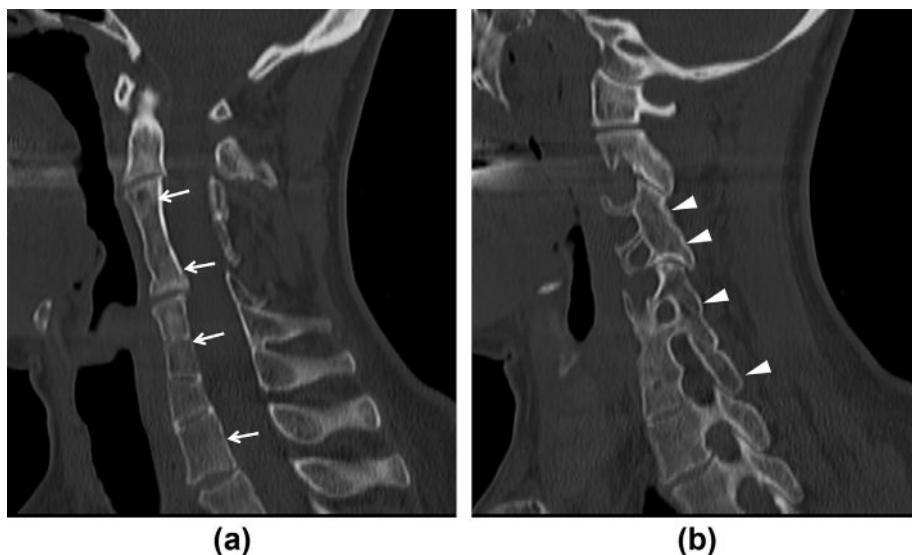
A 47-year-old woman with block vertebrae. Unenhanced CT images of the cervical spine in the sagittal plane showed fusion of the (a) vertebral bodies (arrows) and (b) arches (arrowheads) of C3–C5 and C6–T2.
